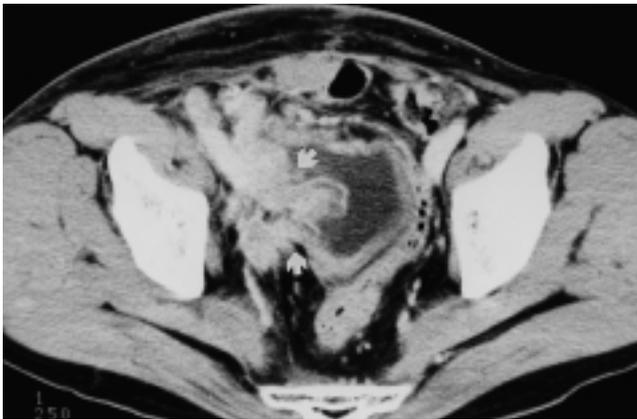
Recurrent tumor at the anastomotic site of the right ureteral insertion site. Post-contrast CT scan shows ill-defined, heterogeneously enhancing mass (arrows) involving right ureteral insertion site of ileal W-neobladder.
